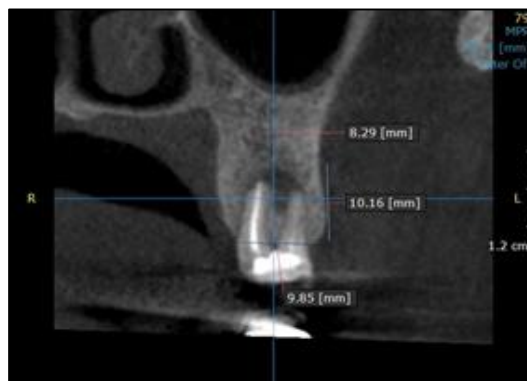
CBCT section of 27
